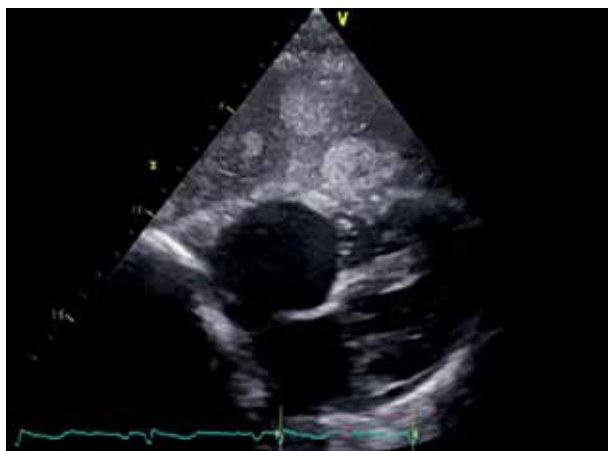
Transthoracic echocardiography (TTE): a 51-year-old patient with carcinoid heart disease and severe tricuspid regurgitation. Subcostal view: huge enlargement of the right atrium and liver metastases
